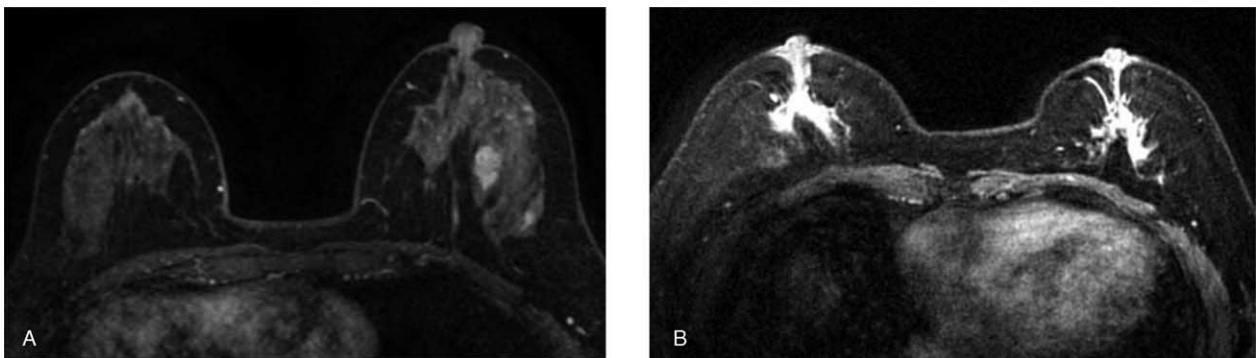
SA features on magnetic resonance imaging (MRI). (A) Irregular even enhancement mass of 26 mm × 21 mm in lateral to the middle of the right breast is noted. BI-RADS 4B. Pathology: DCIS arising from SA. (B) MRI reveals non-mass enhancements inferior to the lateral of both nipples. BI-RADS 4B. Pathology: IDC with DCIS arising from SA.
